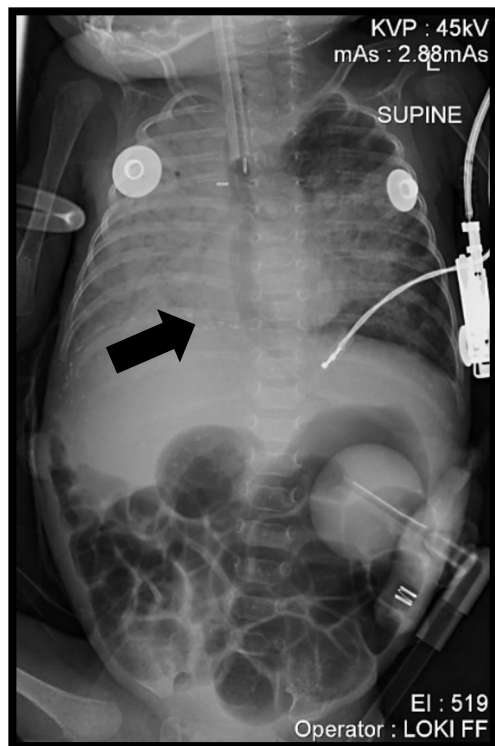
Chest radiograph demonstrating air in esophagus, suggestive of fistula recurrence
